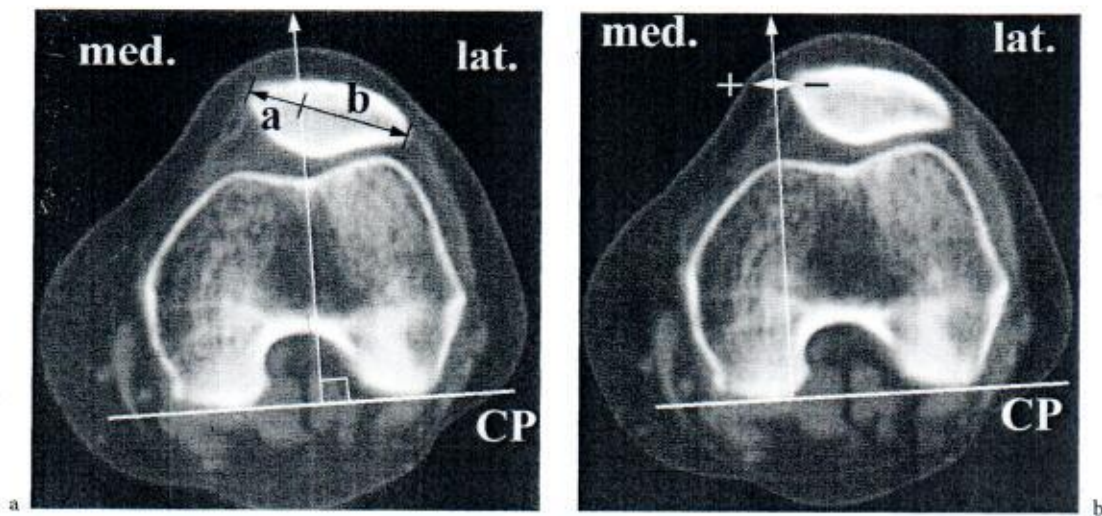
Measurement at CT of lateral patellar displacement according to BROSSMANN et al. a Bisect offset is percentage, $a/b + 100$, of patella lateral to the projected perpendicular line. b Similar to the measurements of LAURIN et al. (Fig. 13.27)
